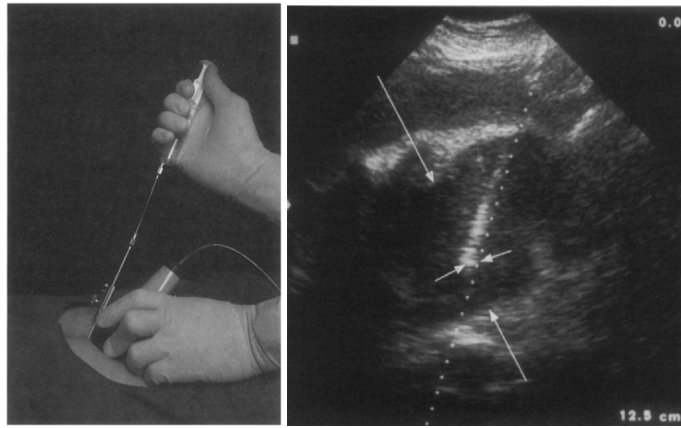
a) Setup of an ultrasound-guided biopsy. b) Typical US image obtained during a biopsy of the caudate liver lobe (arrows). The needle tip (small arrows) is seen in the target. Images from [Holm and Skjoldbye, 1996]
